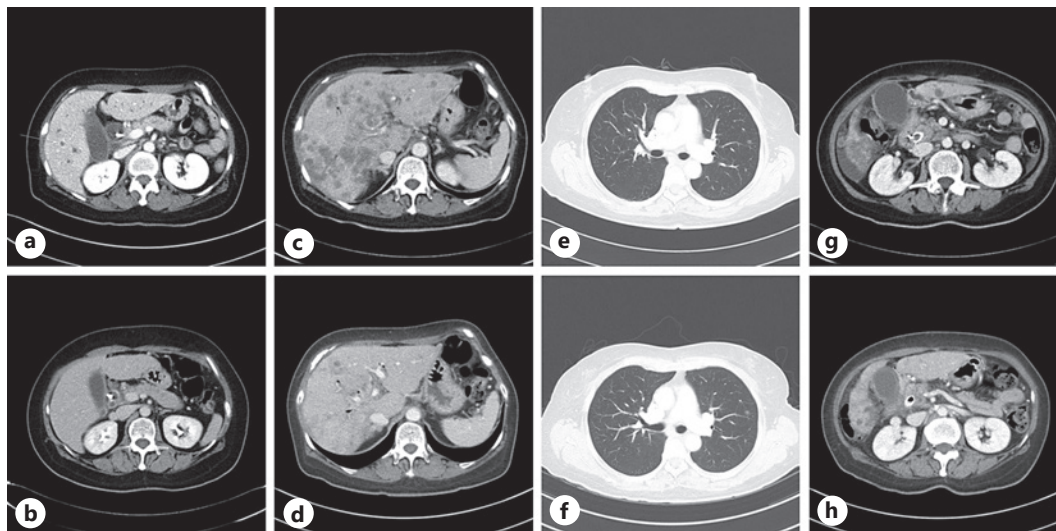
Contrast-enhanced CT images of the abdomen and high-resolution CT images. a Before the treatment with liposomal irinotecan. Primary origin mass of pancreatic cancer and multiple liver metastasis. b After 5 months of liposomal irinotecan. Decreased size of primary origin and disappeared liver metastasis. c–e Before the rechallenge with liposomal irinotecan. Extensive multiple liver metastasis, ascites, increased size of origin mass, and lung metastasis. f–h Six weeks after rechallenge with liposomal irinotecan. Improved multiorgan metastasis and decreased origin mass size.
